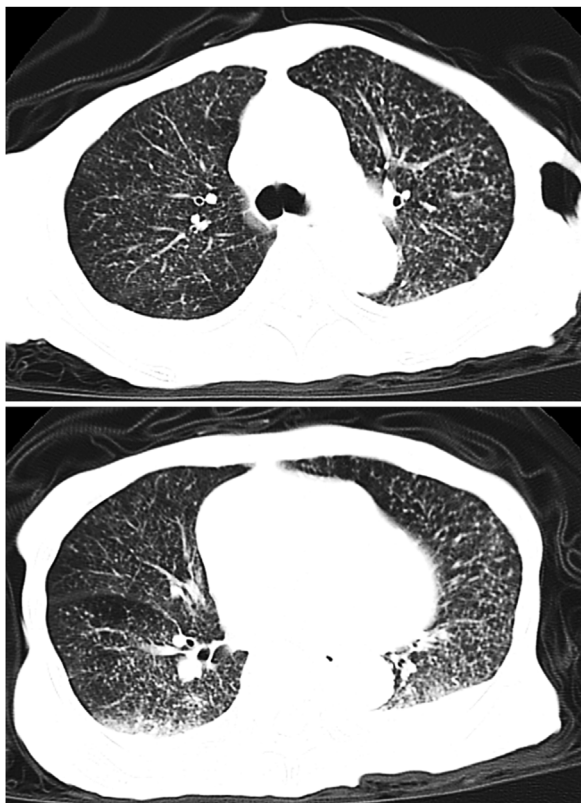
Chest computed tomography showing diffuse, bilateral, widespread miliary opacification.
